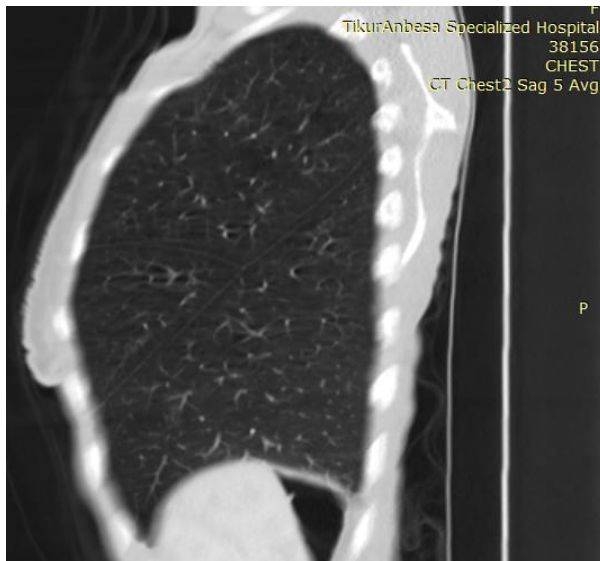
Representative sagittal chest CT image of the left lung demonstrating presence of left minor fissure thus trilobed left lung.
